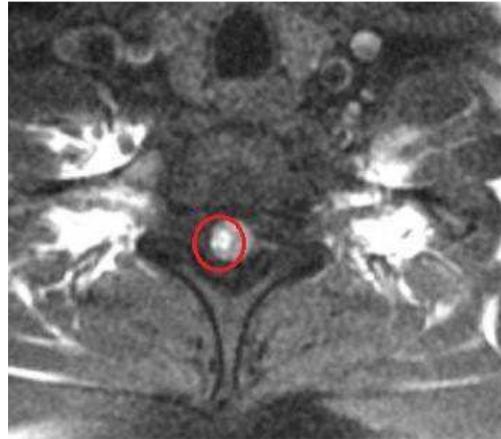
T2 MRI - Transverse view.
